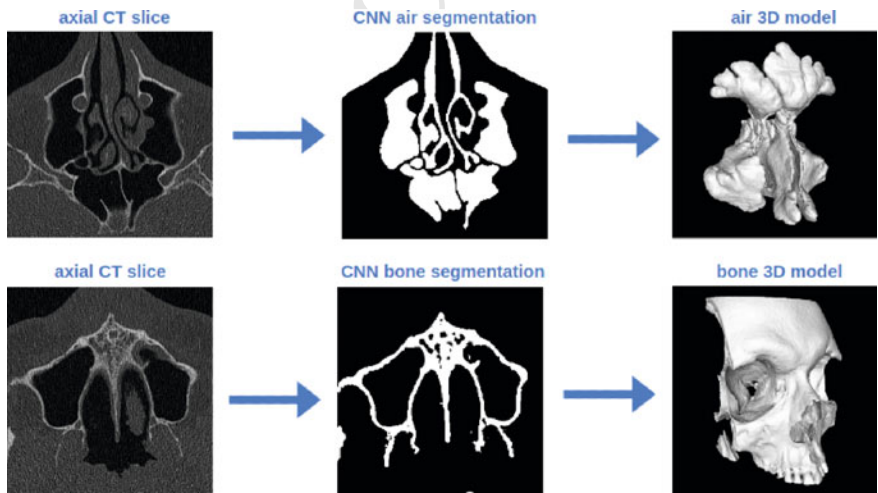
CT slices, corresponding automatic segmentations and 3D models generated from these
